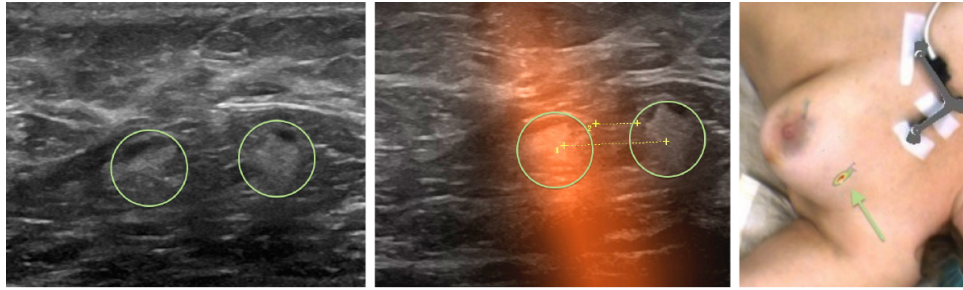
Freehand SPECT for SLN biopsy in the axilla. On the left: an US image depicting two LNs (highlighted in green). In the center: an overlay between an US image and the respective cross section of the freehand SPECT volume. The additional functional information added to original image allows to infer that the left LN is marked with the radiotracer, and hence is the SLN. While the US image updates in real time, the same can not be said for the SPECT volume which is acquired intraoperatively just before the beginning of the biopsy. On the right: the operating site of a freehand SPECT and US guided SLN needle biopsy. The optical marker visible on the chest of the patient is used to maintain the alignment between the anatomy and the acquired volume; but it cannot help against eventual deformations of the soft tissue of the breast.
